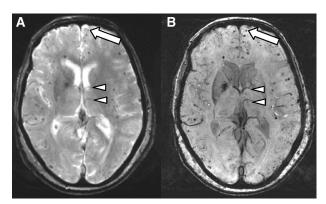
A shows T2*-weighted gradient-recalled echo (axial plane). Multiple cerebral microbleeds (CMBs) are evident as small hypointensities (the arrow points to an example). Cerebral veins are seen only faintly (arrowheads). B shows susceptibility-weighted imaging (axial plane) from the same level in the same patient. CMBs are more prominent compared with surrounding tissue (arrow), but cerebral veins (arrowheads) and basal ganglia iron deposition are more prominent as well. (See Methods for details of the MRI acquisition.)
